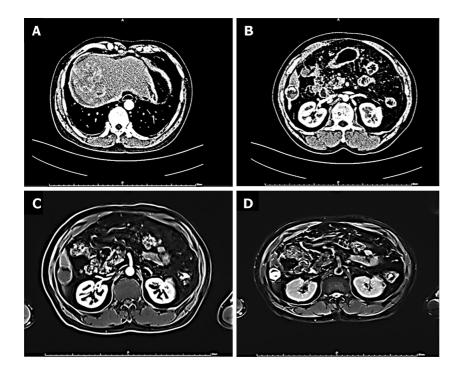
Medical images. A: Abdominal computed tomography revealed an uneven enhanced lesion located S4/8 segment of liver; B: Abdominal computed tomography revealed a mass in the S6 segment of the liver with a thick calcified wall; C and D: Magnetic resonance images revealed that lesion can be observed at S4/8 segment of liver, with long T1 and mixed with T2 signal.
